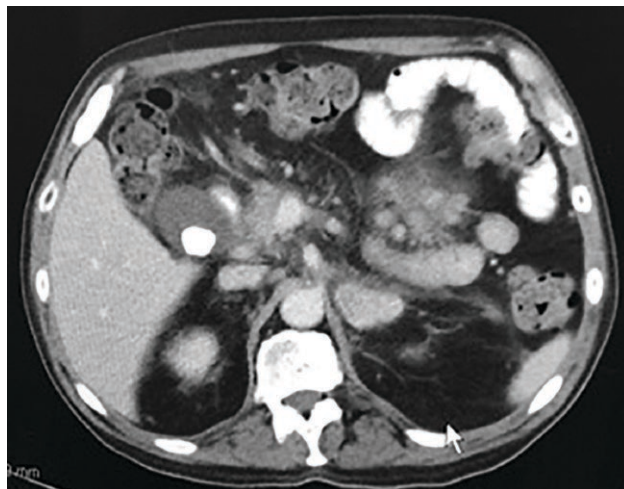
CT of the patient's abdomen showing a thickened, indurated mesentery.
